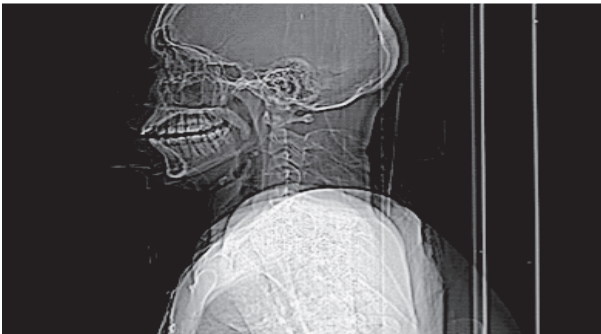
Lateral Cervical Spine X-ray Revealing No Evidence of C1-C2 Subluxation
